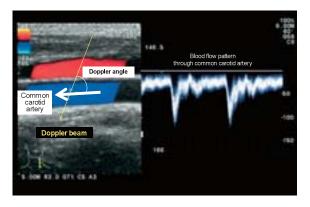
Correction of angle for pulse Doppler blood flow patterns (left: the distal side)
